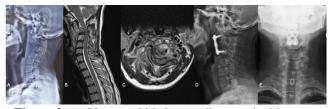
A 38-year-old lady was diagnosed with upper cervical tuberculous spondylitis after a 2-month history of neck pain. Plain radiograph and MRI showed destruction of C2-C3 vertebral bodies with severe local kyphosis, kyphotic angle 39.66 degrees (A-C), anterior-only approach was done and final follow-up radiographs showed good fixation and fusion (D-E).
